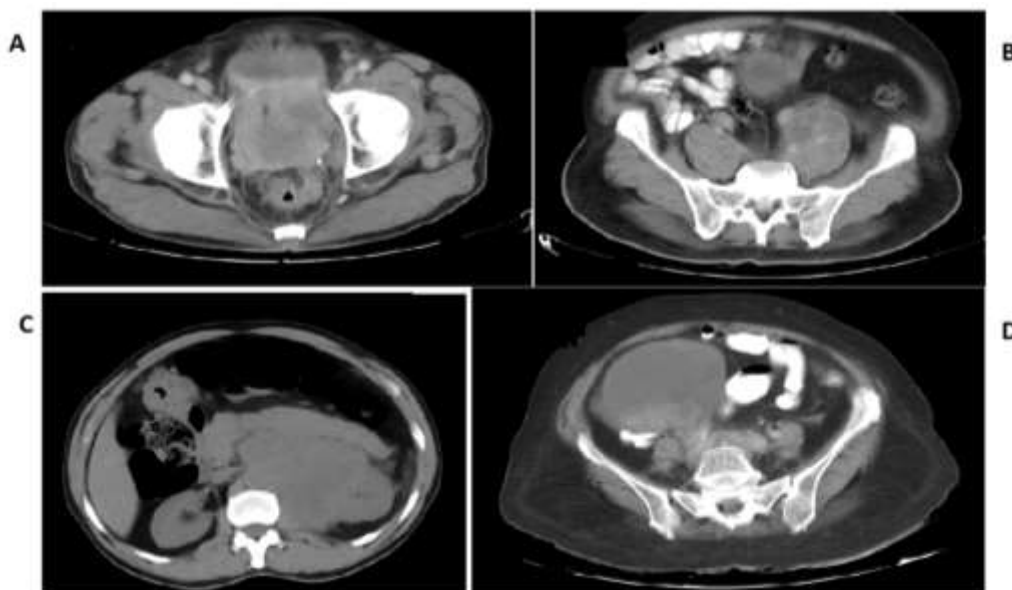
(A): Computed Tomography (CT) of the pelvis showing large prostatic mass with infiltration of bladder base and seminal vesicles
